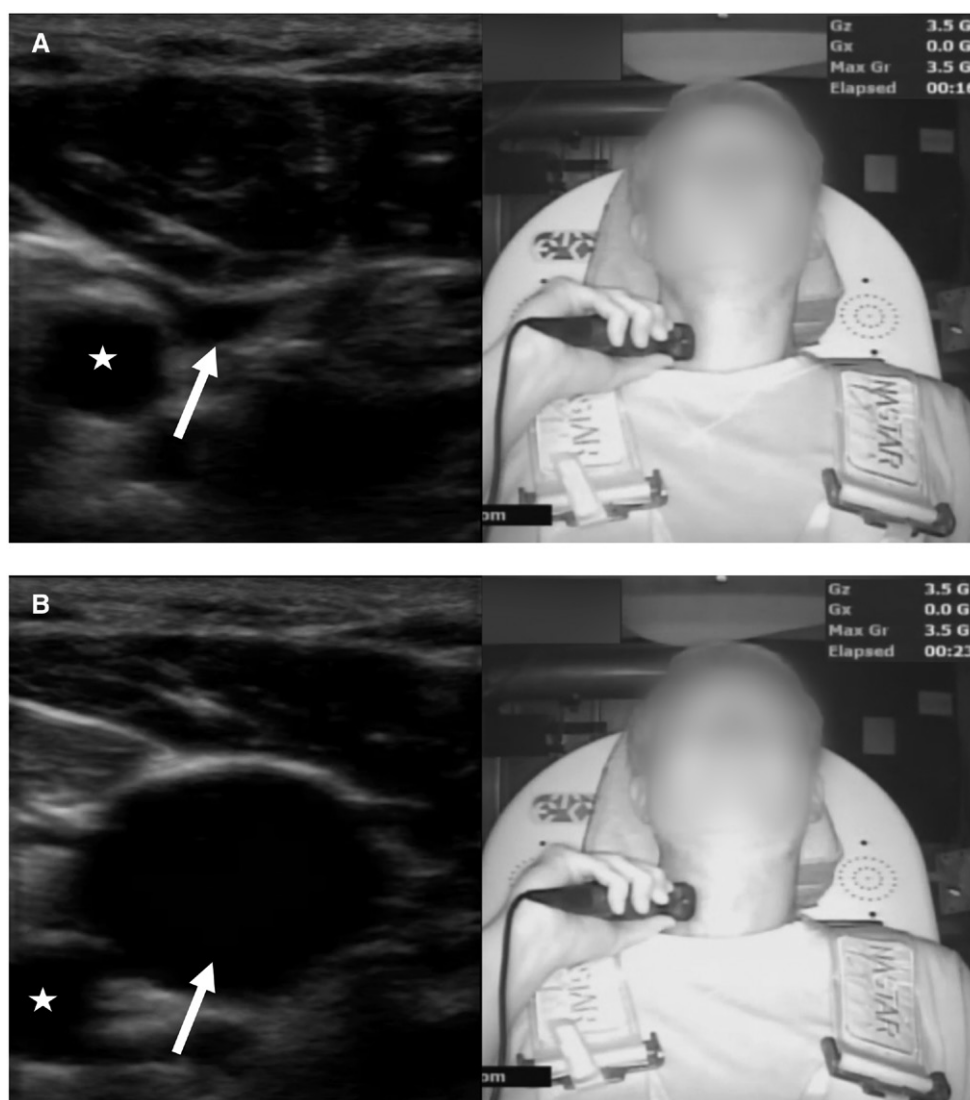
Jugular imaging by a novice sonographer (Subject 3). A) Jugular vein as imaged by a novice sonographer while relaxed at +3.5 G_z . B) Jugular venous distension as imaged by a novice sonographer performing an anti-G straining maneuver at +3.5 G_z . The carotid artery is marked by a white star; the jugular vein is indicated by a white arrow.
